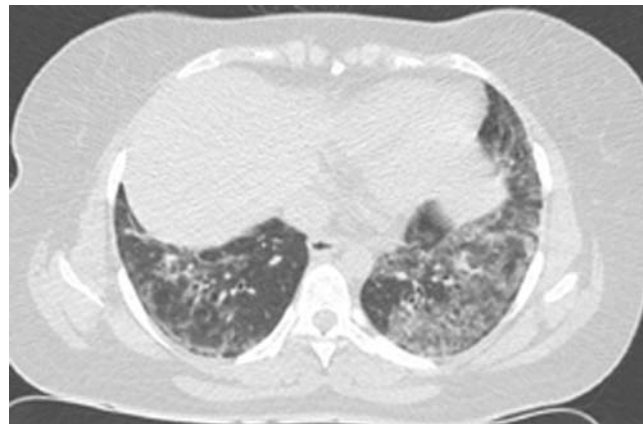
High resolution computed tomography image of a patient with Sci-70 positive systemic sclerosis and biopsy-proven fibrotic nonspecific interstitial pneumonia. The disease is predominantly basal and consists of a mixture of ground-glass attenuation and fine reticular abnormalities, in association with traction bronchiectasis.
